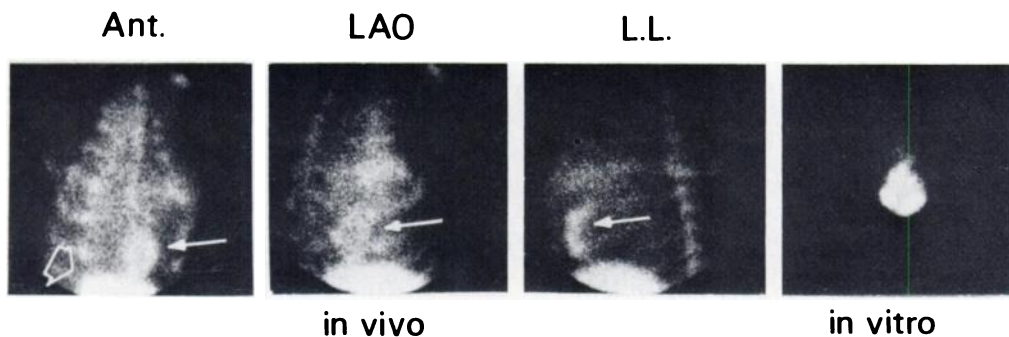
Scintigrams as in Fig. 2, but at 48 hr after LAD occlusion. Small arrow shows uptake in damaged myocardium. Open arrow shows liver uptake, and there is some uptake in bones. Far right panel shows scintigram of the excised heart in the LAO position.
